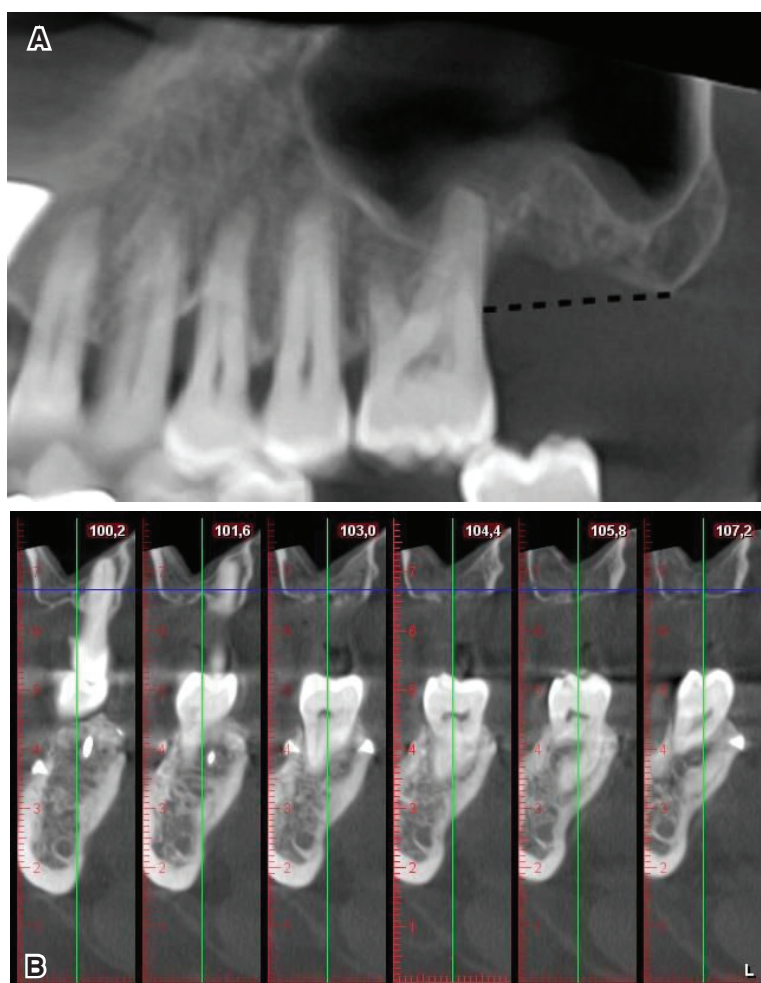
Preoperative evaluation via CBCT showing the extent of supracrestal bone defect and periodontal defect in tooth 26 (a–b).
